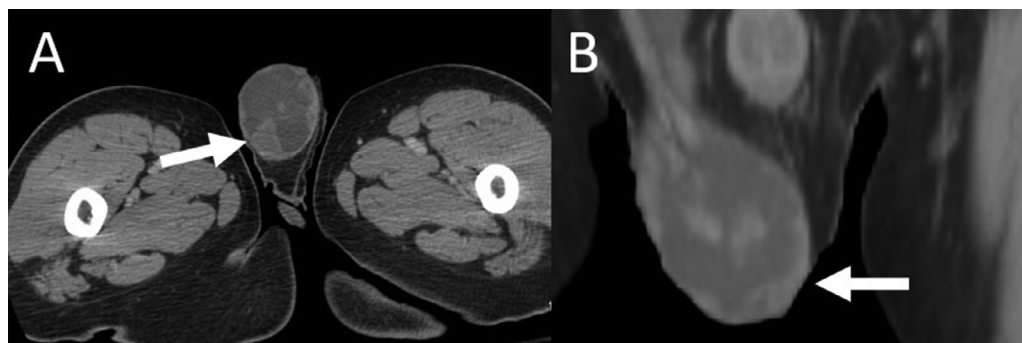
(A) Axial contrast enhanced computed tomography image at the level of the scrotum. The large right hydrocele is again seen, with solid (arrow) and cystic extra-testicular nodules. (B) Coronal contrast enhanced CT image shows the enhancing nodules (arrow) within the right hydrocele extending superiorly to the level of the inguinal canal.
